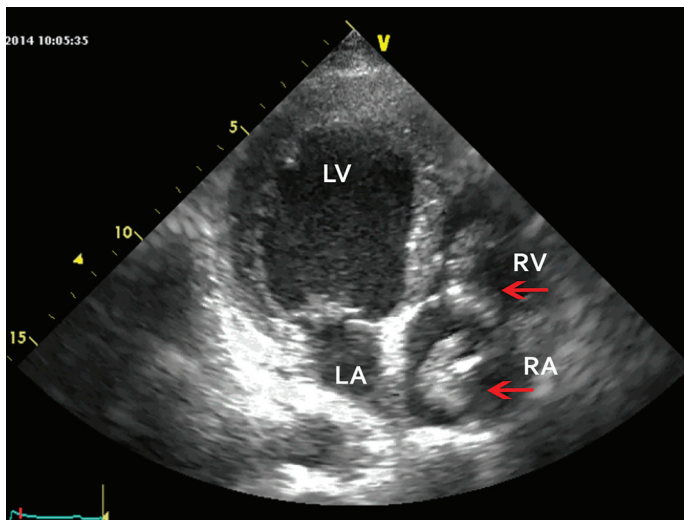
Transthoracic echocardiography, four-chamber view: a large polylobulated echogenic and highly mobile mass occupies most of the right atrium and prolapses through the tricuspid valve and remains trapped in systole (red arrows; RV, RA - right ventricle and right atrium; LV, LA - left ventricle and left atrium)
